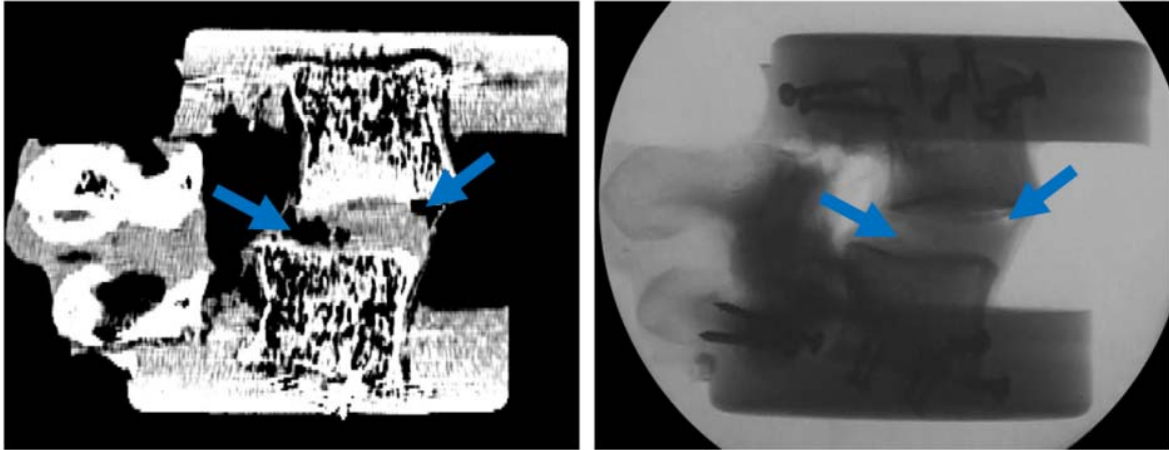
Example of X-ray (left) and CT scan (right) showing disc luxation at FSU 3021 L4-L5 (arrows indicate detachment).
